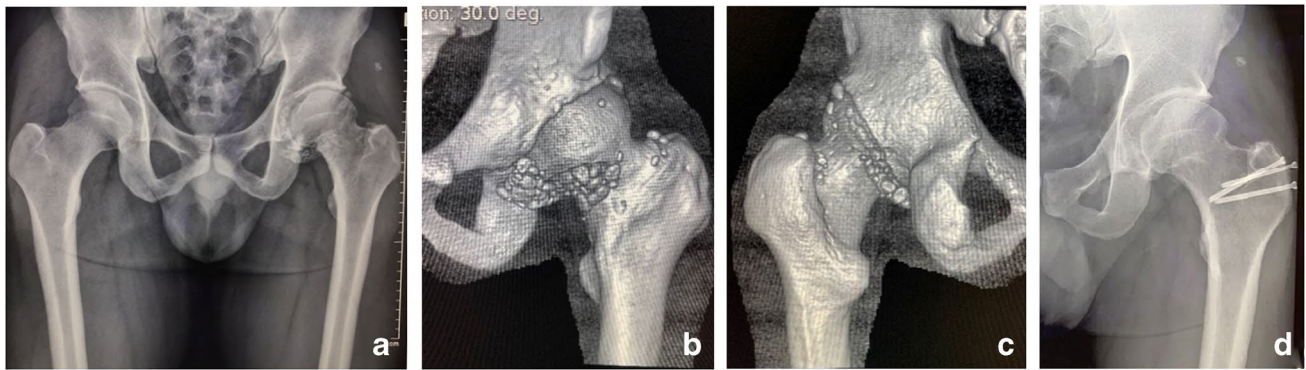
A 31-year-old man presents with pain and limited motion in the left hip for 2 years. a–c Pre-operative radiograph (a) and three-dimensional CT (b–c) showing multiple loose bodies filling the hip joint. d Radiograph at 42 months post-operatively
